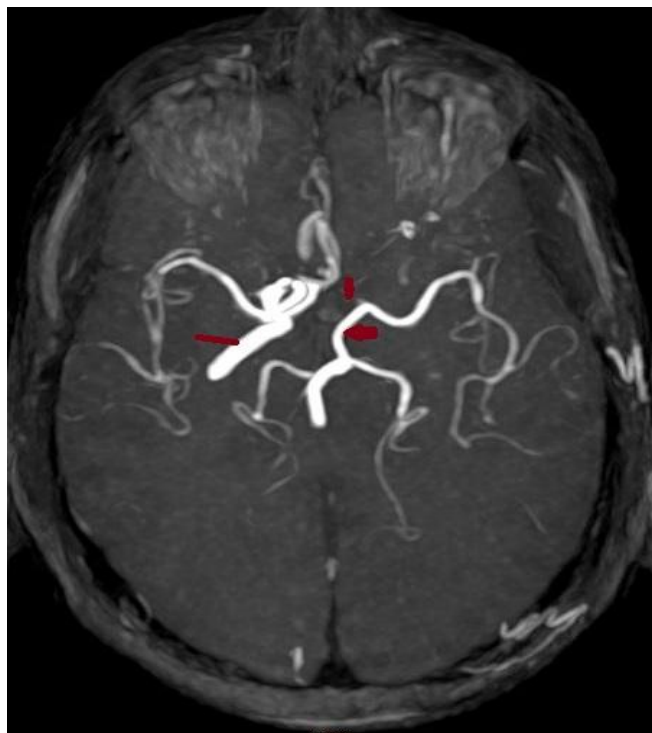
Cerebral MRI angiography (TOF) showing the left ICA absence with normal right ICA (large red line). It shows the basilar artery supplying the left middle cerebral artery via the left posterior communicating artery (red arrow). Absence of the A1 segment (small red line) is noted.
